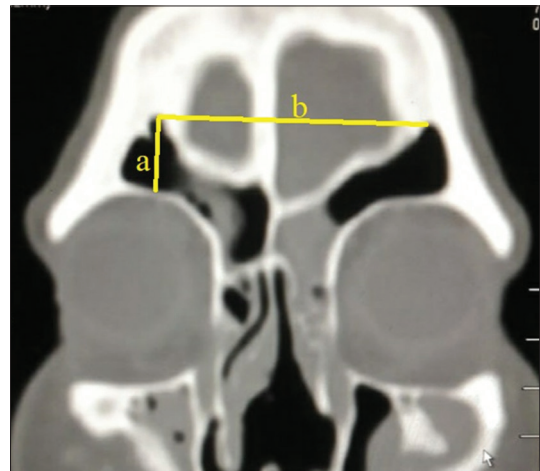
Coronal computed tomography scan showing the frontal sinus height (a) and the distance between the highest points of the two sinuses (b)
